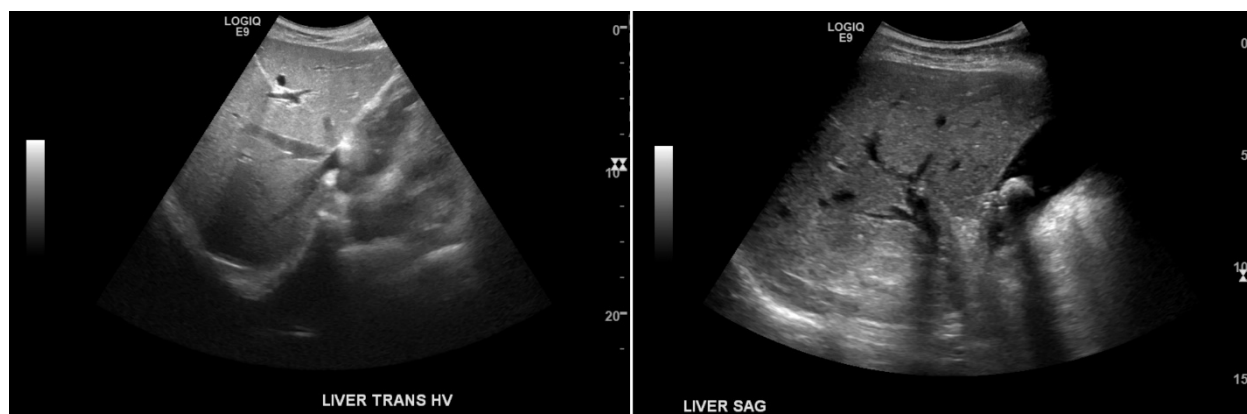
Ultrasound scan showing increased echogenicity of the liver in comparison to echotexture of the renal cortex (not shown here): grade I-II fatty liver
